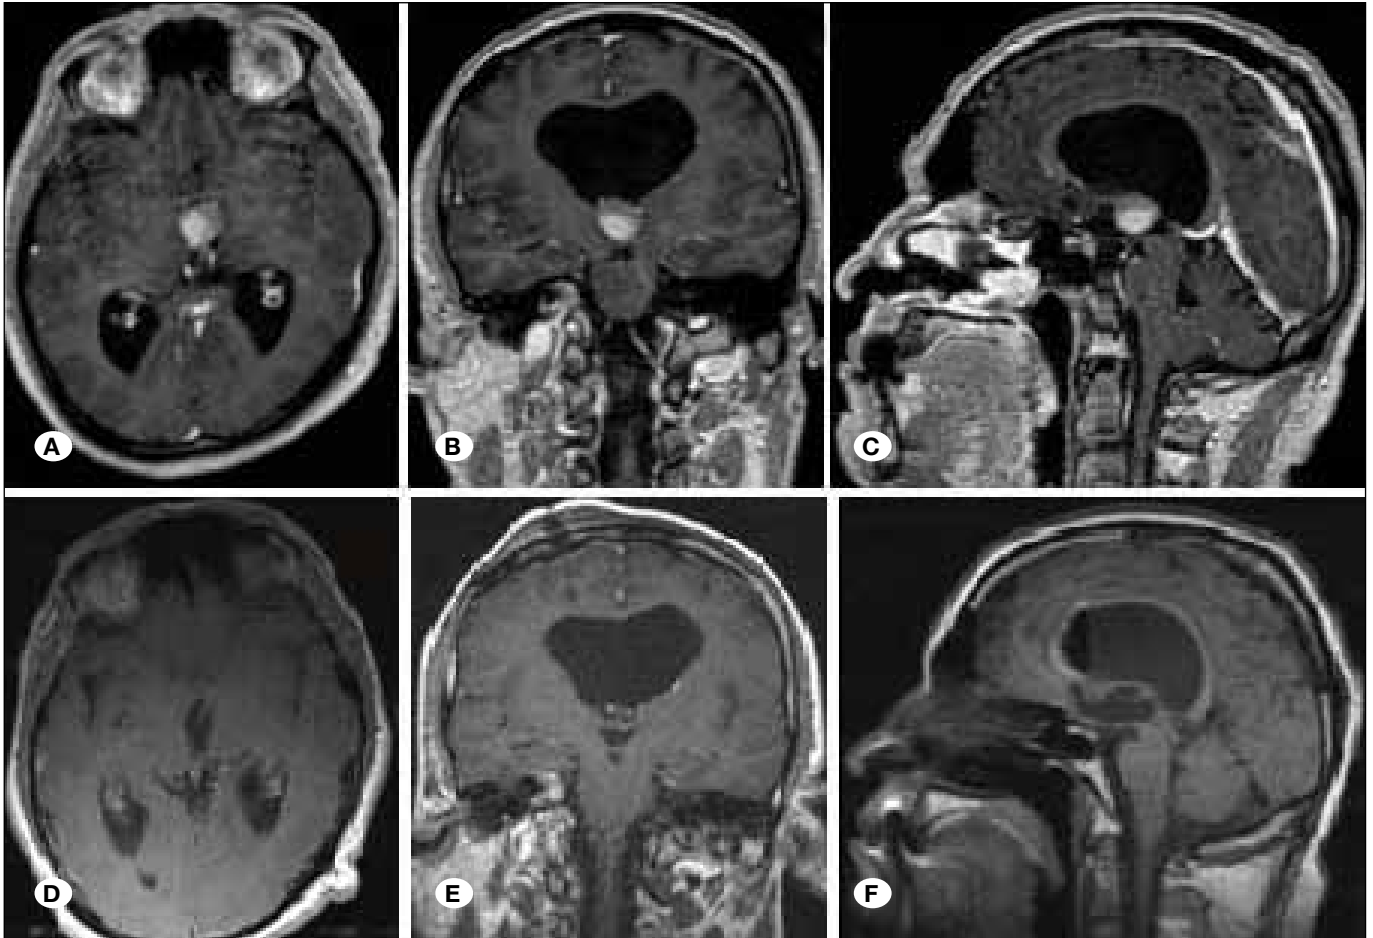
Preoperative (A,B,C) and postoperative (D,E,F) axial, coronal and sagittal T1 W postcontrast MR images of patient 39, show total removal of the colloid cyst located centrally in the foramen of Monro.
